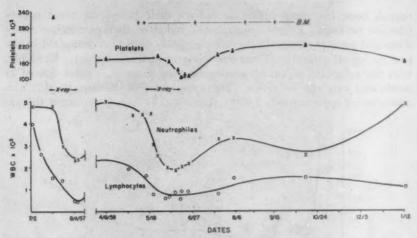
Case 3. Control. July, 1957-January, 1959. The x-ray factors were the same as for case 1. The first course of radiotherapy, 7/19/57 to 8/15/57, was to five ports varying from 10 by 15 to 15 by 15 cm., including right iliac, umbilical, lumbar, epigastric and low dorsal areas, 400 r daily, total, approximately 2,000 r (tissue) to the node-bearing regions. The second period of radiotherapy, 5/16/58 to 6/16/58, was to 4 ports, 10 by 15 cm. each, including supraclavicular and opposing mediastinal ports, 400 r daily, 2,400 r (tissue) total.
